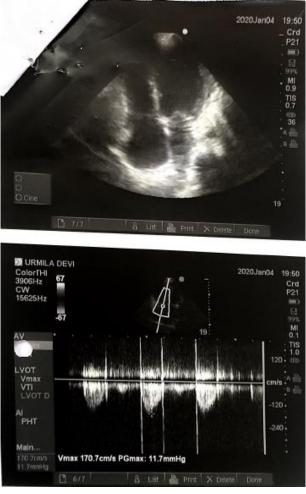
Doppler echocardiography showed dilated left ventricle, dilated right ventricle and right atria with mild mitral regurgitation.
